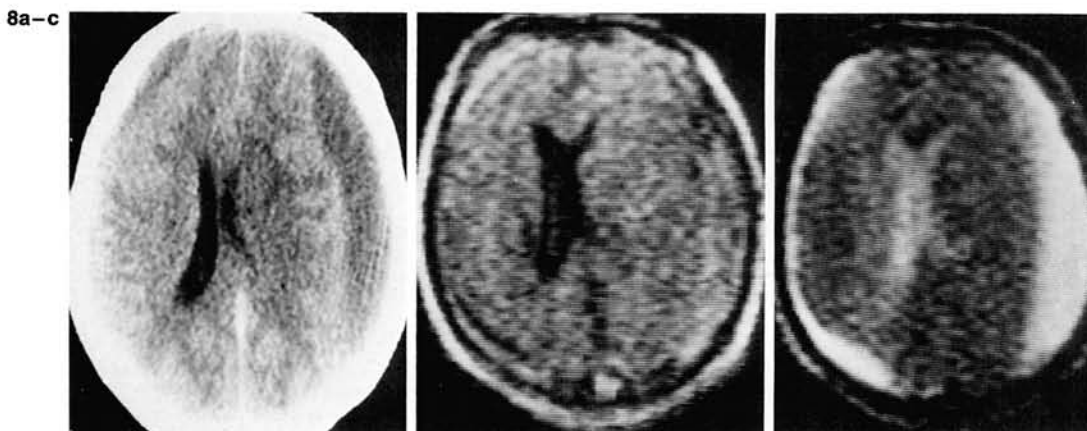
Chronic subdural hematoma is hypodense on noncontrast CT scan (a), is faintly visualized in the inversion recovery 1,000(200)/70 image (b), but is clearly discernible in the spin echo 2,000/160 image (c) at 0.02 T.
